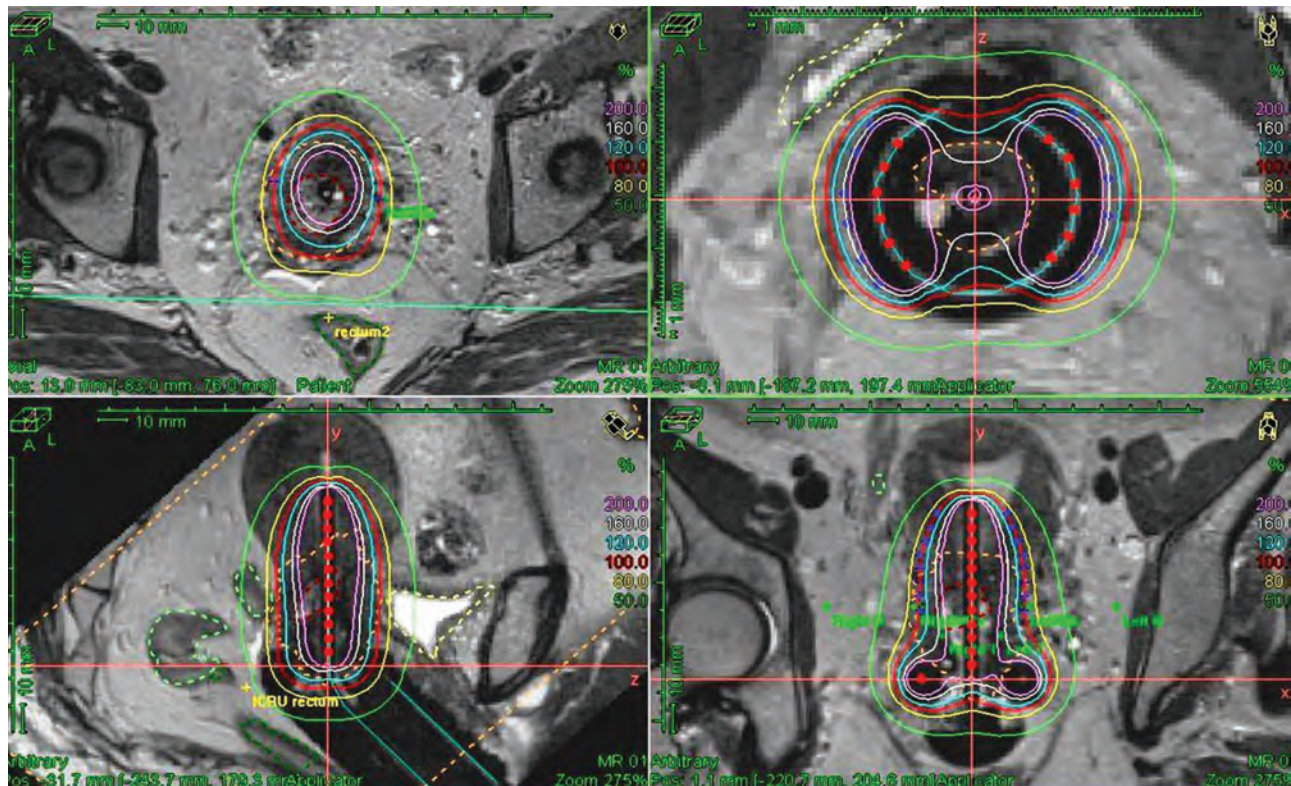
Delineation and dose distribution at 3rd brachytherapy application on MRI with Tandem and ring applicators in place: CTV_{HR}, orange; GTV_{res}, red; bladder, thin yellow; rectum, dark green; sigmoid, light green; isodose lines normalized to 5.5 Gy: green is 50%, yellow is 80%, red is 100%, cyan is 120%, white is 160%, pink is 200%. These doses correspond to 2.75, 4.4, 5.5, 6.6, 8.8, and 11 Gy per fraction, respectively.
